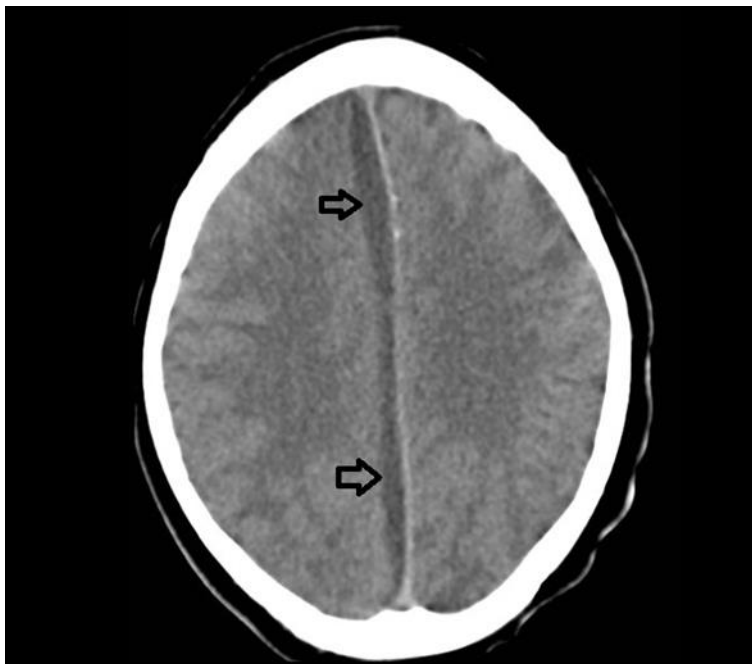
Axial non-contrast enhanced CT of the brain
